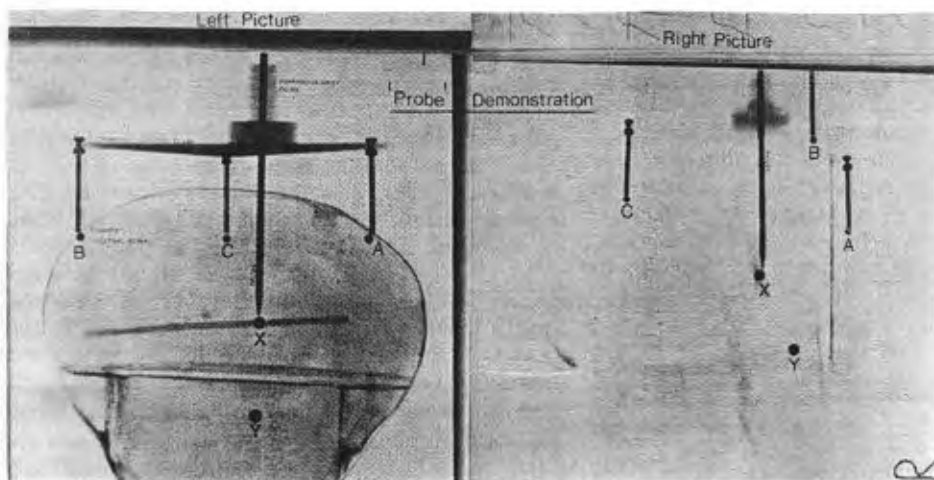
X-rays showing a three legged device and a vertical pointer, whose tip is in contact with target X (from Adams, 1981)
